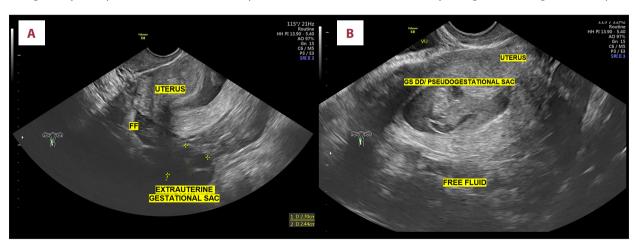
Transvaginal ultrasonography reveals gestational sac with free fluid. (A) shows a gestational sac in right adnexal volume 1.0×7.4×1.9 cm with ring of fire. (B) Suspected intrauterine gestational sac with probable pseudo-gestational sac. FF – free fluid; GS – gestational sac.
